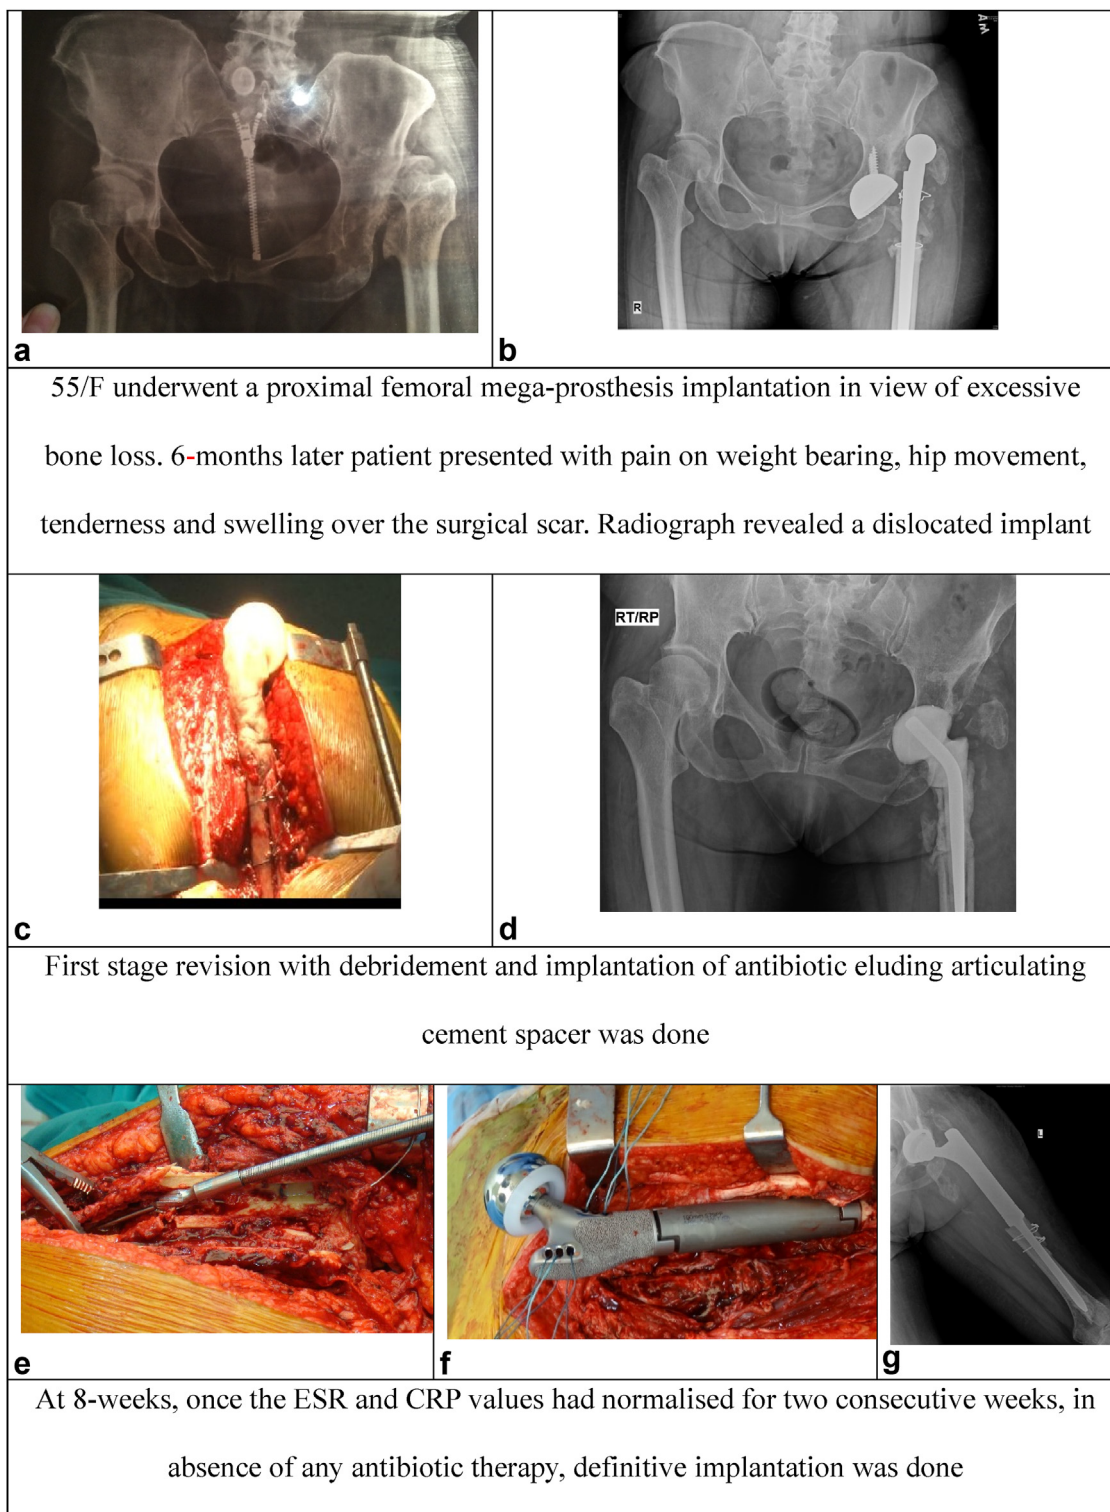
Case II, a 55-year-old female patient, underwent a proximal femoral megaprosthesis implantation in view of excessive bone loss. Six months later, the patient presented with pain on weight bearing, hip movement, tenderness, and swelling over the surgical scar. Radiograph revealed a dislocated implant (a and b). First-stage revision with debridement and implantation of antibiotic eluding articulating cement spacer was done (c and d). At 8 weeks, once the ESR and CRP values had normalized for 2 consecutive weeks, in absence of any antibiotic therapy, definitive implantation was done (e, f, and g). At 4-year follow-up, radiograph shows well-seated implant. Patient is able to carry out all activities of daily living without complaints (h, i, j, and k).
